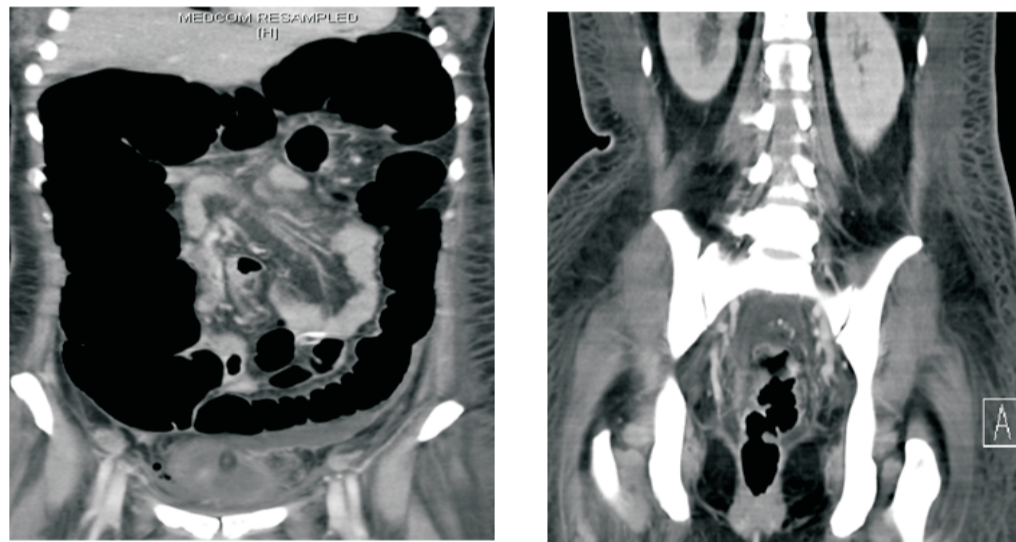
CT Abdomen shows dilated large bowel with distal tapering and some narrowing at the presumed anastomotic site at the rectum. Impression was Mechanical obstruction.
